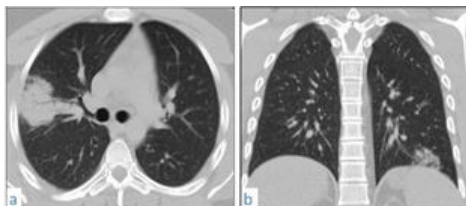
31-year-old male patient with COVID-19, CT chestaxialimage (a) shows right upper lobe predominantly subpleural consolidation with air bronchogram, coronal image (b) shows left lower lobe subpleural consolidation with traction bronchiectasis. (CORADS VI and CT severity score – 7/25 -mild).
